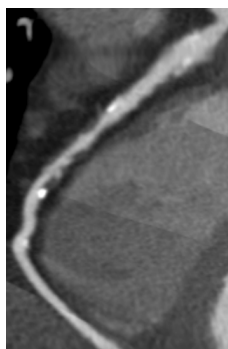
A right coronary artery by coronary computed tomography angiography. There is a high burden of non-calcified and mixed coronary plaques throughout the entire vessel, and a 50-70% luminal narrowing in the mid segment.
